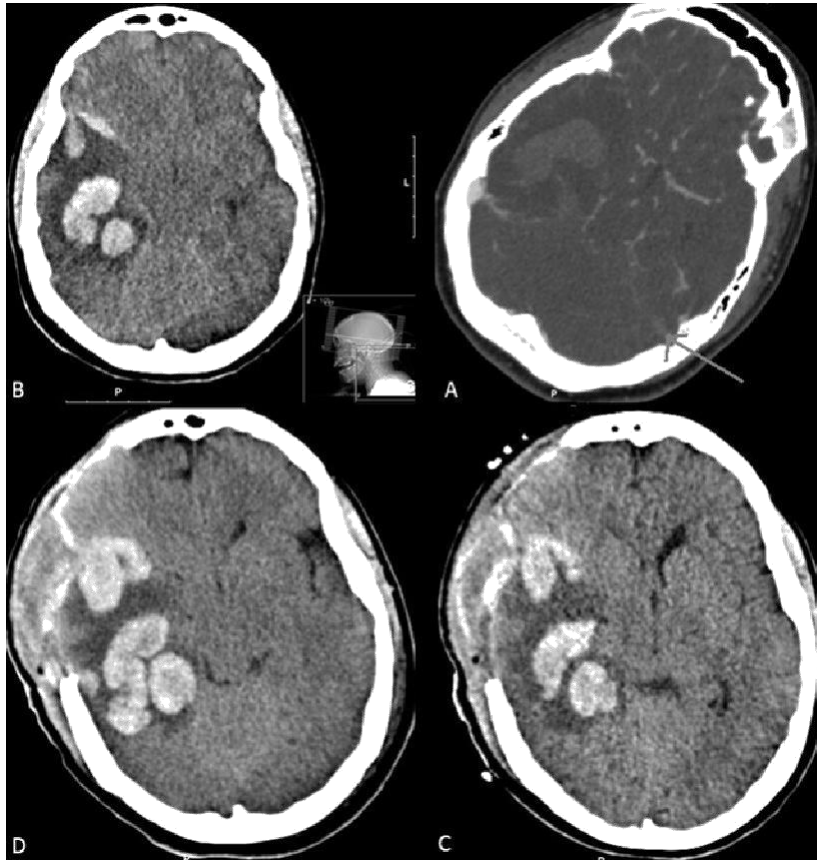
A- CT-Angio in venous phase showing a right temporal intracerebral Hemorrhage and a filling defect in the left sigmoid sinus marked with an arrow correlating to a sinus vein thrombosis. See the right sigmoid sinus bulb filled with contrast for comparison; B- A non contrast enhanced CT showing the Intra-cerebral hemorrhages. See the mild hyperdensity seen in the ri; C and D- A non contrast enhanced post-operative CT of the same patient. After undergoing a right frontal decompressive craniectomy showing a mild enlargement of the parenchymal hematoma after decompression.
